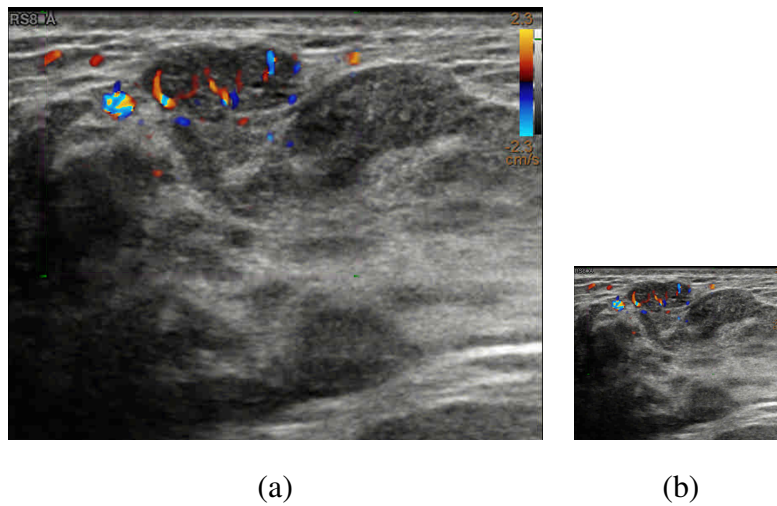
(a) Original size of Power Doppler image 996×812 . (b) 25% of actual size 249×203 .
